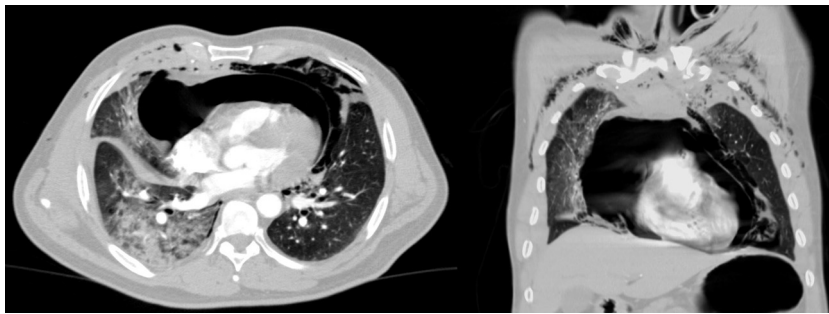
Computed tomography scans on arrival, axial and coronal planes. An expressive non-tension pneumopericardium is present. Pneumomediastinum, subcutaneous emphysema and right lung contusion can also be noticed.
